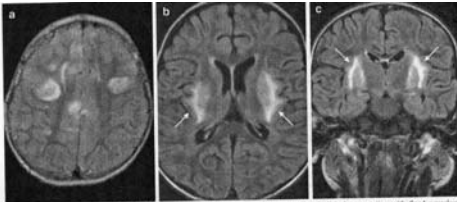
EBV encephalitis. a Axial FLAIR image demonstrates abnormal T2-W signal in the bilateral frontal cortex and subcortical white matter. This is a typical pattern for viral encephalitis. The multiple vascular territories territorial malar inclusion bodies. Additionally, a child presenting with multiple strokes of this magnitude would have a profound clinical presentation with focal neurologic deficits. b, c Axial (b) and coronal (c) FLAIR images demonstrate increased signal in the bilateral basal ganglia reflecting the unique tropism of EBV for this area.
